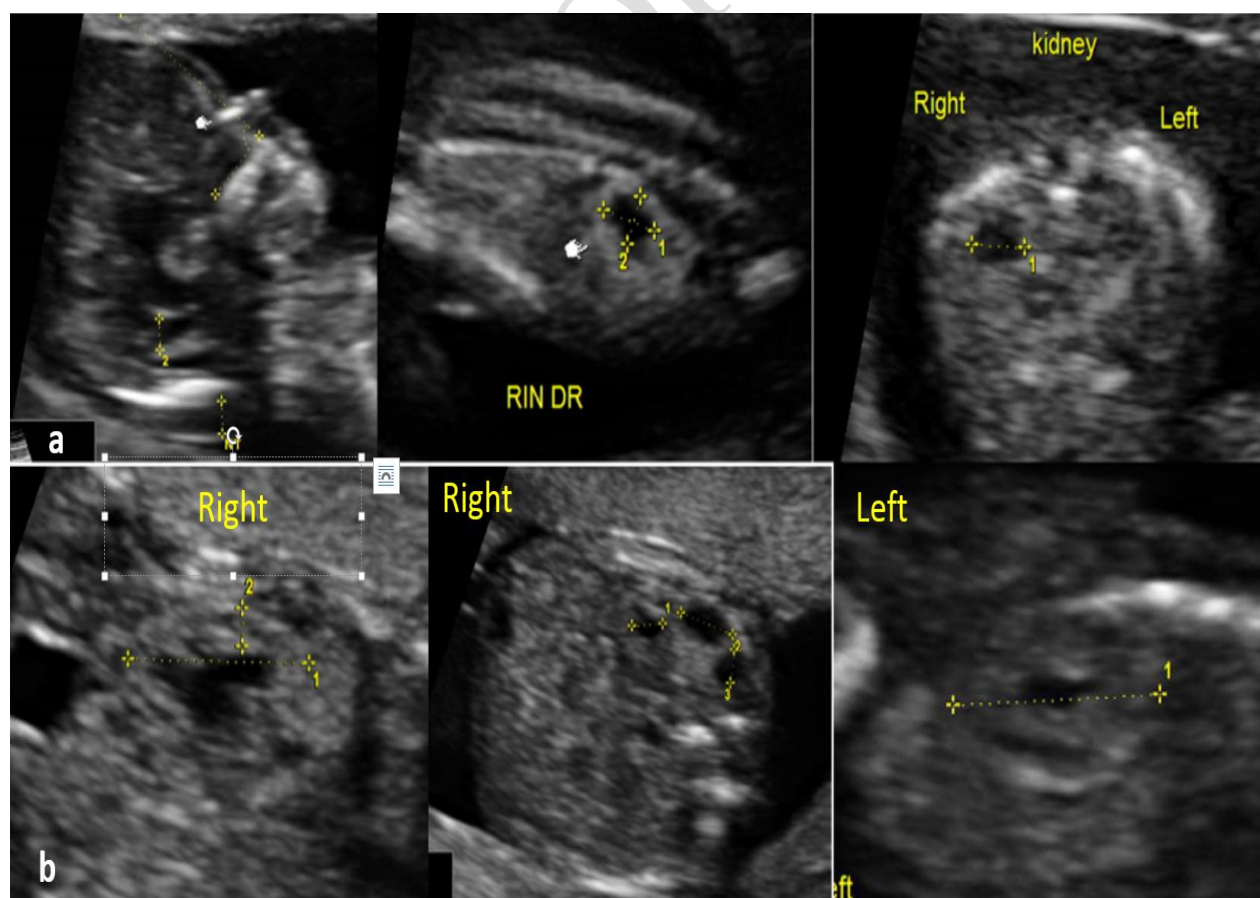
Case 3, ultrasound features 11+3 gestational weeks (a) and 16+2 gestational weeks (b).
